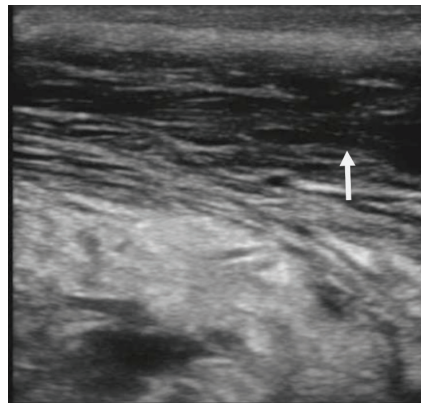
Ultrasonographic changes In udder edema
